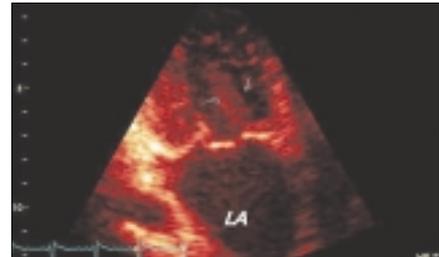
Three-dimensional transthoracic echocardiographic assessment of the papillary muscle directly attached to the basis of the anterior mitral valve
